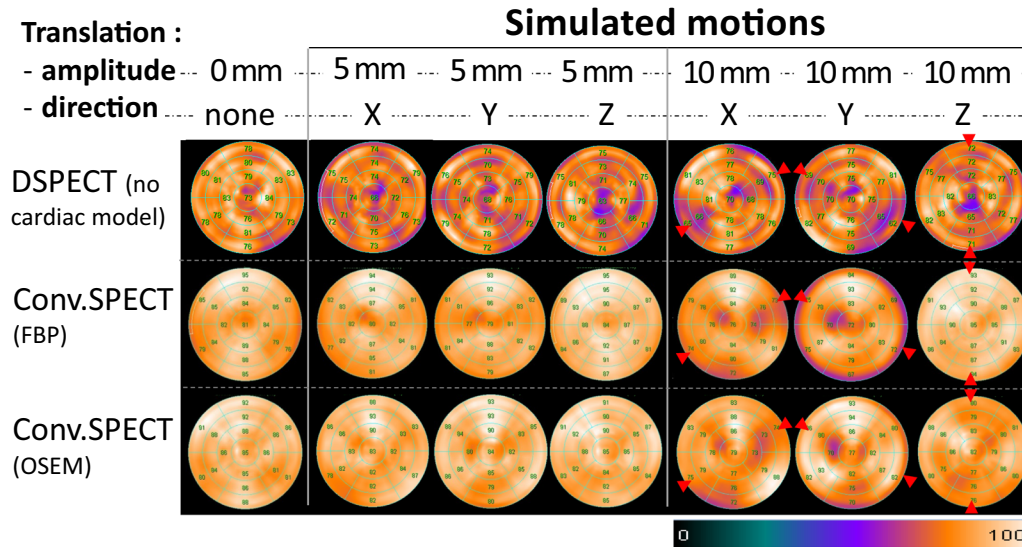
Polar maps of the SPECT images obtained at baseline and for 5- or 10-mm translations in the positive X, Y, or Z directions with the DSPECT camera after exclusion of the recommended cardiac model, and for conventional SPECT images reconstructed with OSEM without RR or FBP as opposed to the recommended OSEM-RR method. Red arrows, corresponding to the translation direction (see Figure 5), are additionally inserted on the polar-maps obtained with the 10-mm motions.
